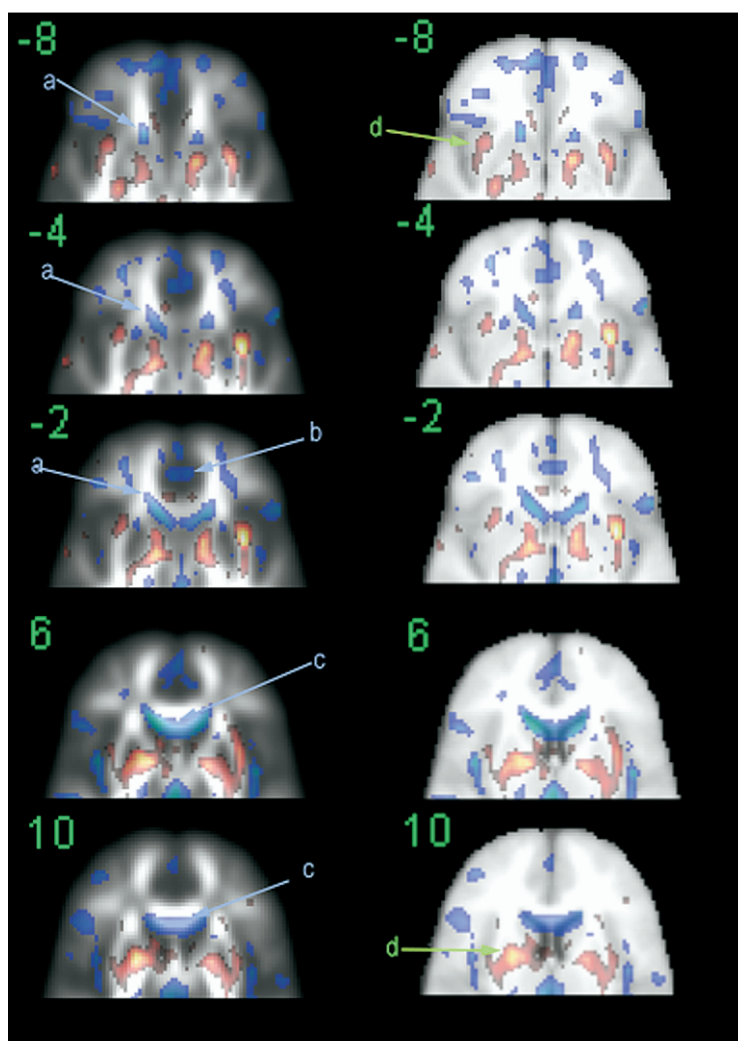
Frontal region anisotropy maps. Significance probability maps as in Figure 1 presented on backgrounds of average anisotropy (left column) and average co-registered anatomical magnetic resonance imaging (right column). Talairach z levels are given as green numerals. Note regions in anterior end of internal capsule and adjacent anterior thalamic radiations and anterior tip of caudate nucleus (A), cingulate gyrus (B), and corpus callosum (C). Areas of increased anisotropy include the insula (D, slice -8) and the putamen and globus pallidus (D, slice $+10$).
